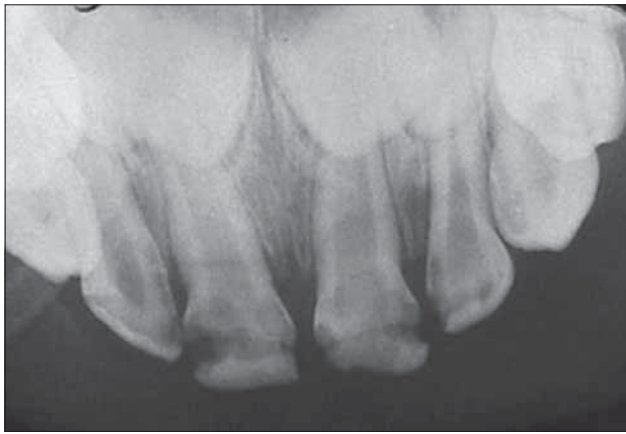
Preoperative radiograph of central incisors with moderate/severe caries in a 2-year, 5-month-old patient.
